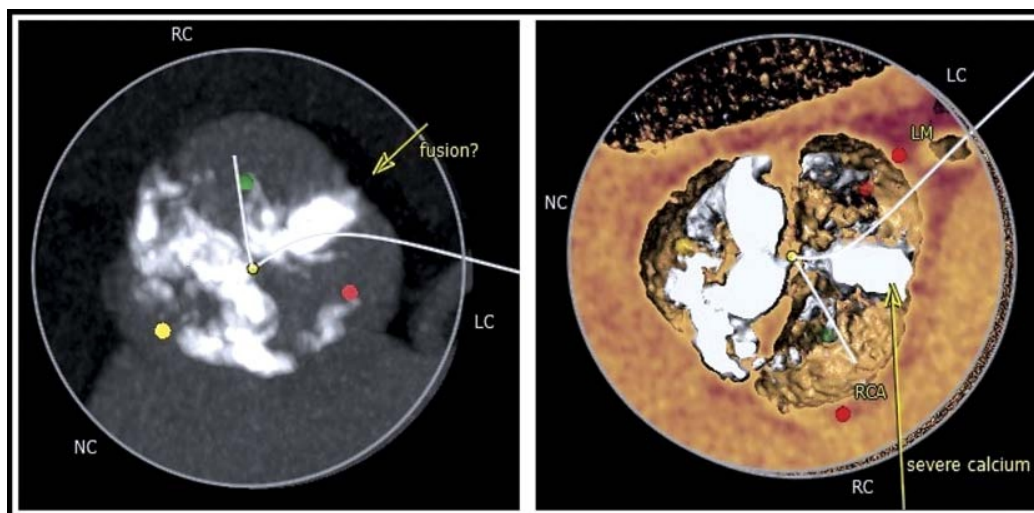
Computed tomographic scan reconstruction of the stenosed native aortic valve showing distribution of calcification in the leaflets and aortic annulus; severe calcification is observed in the area between the left and right cusps with possible leaflet fusion. LC, left cusp; LM, left main stem; NC, noncoronary cusp; RC, right cusp.
